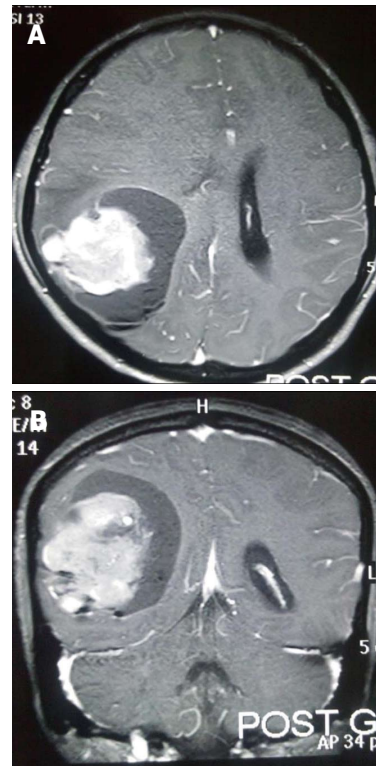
Post contrast magnetic resonance imaging axial (A) and coronal (B) images shows large heterogeneous lesion in right parieto-occipital region with effacement of ipsilateral lateral ventricle.
